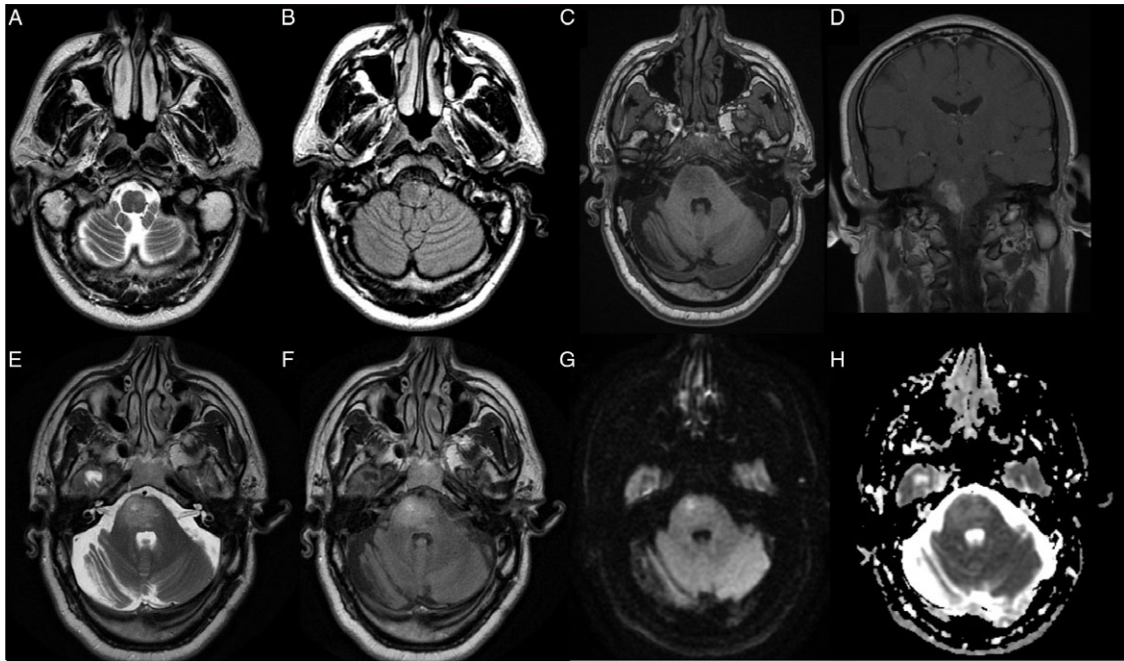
MRI at diagnosis revealed a small area of hyperintensity on T2-weighted imaging (A) and fluid attenuation inverse recovery imaging (FLAIR, B) at the level of the left inferior olivary nuclei. On representation, MRI revealed a large parenchymal lesion of the right pons on T1-weighted imaging (C), with enhancement visible in the coronal view (D). This was also observable in the axial view on T2-weighted imaging (E), FLAIR (F), diffusion-weighted imaging (G), and apparent diffusion coefficient imaging (H).
